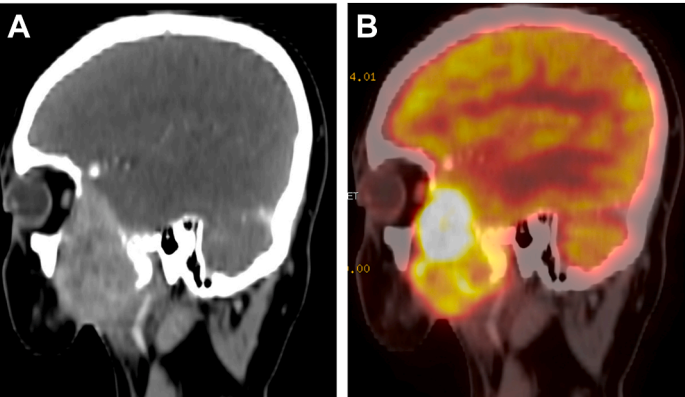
(A, B) Imaging depicting pattern of failure after conventional resection and adjuvant treatment, infratemporal fossa recurrence ([A] CT scan, [B] PET CT scan).
